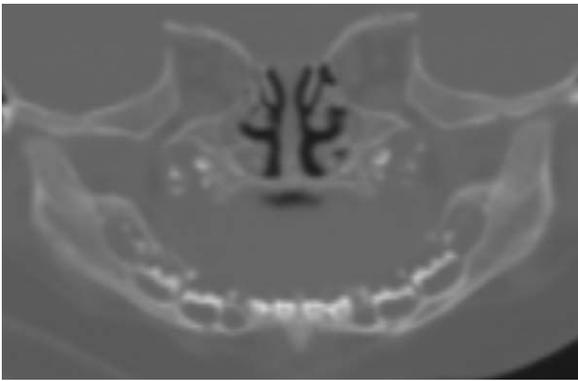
A curved MPR CT image resembling an OPG. Note the indistinct appearance of the lower deciduous incisors. The occlusal surfaces of the deciduous mandibular molars appear complete and some calcification is visible in the developing mandibular permanent molar sites. Chronological age is 3 months.
